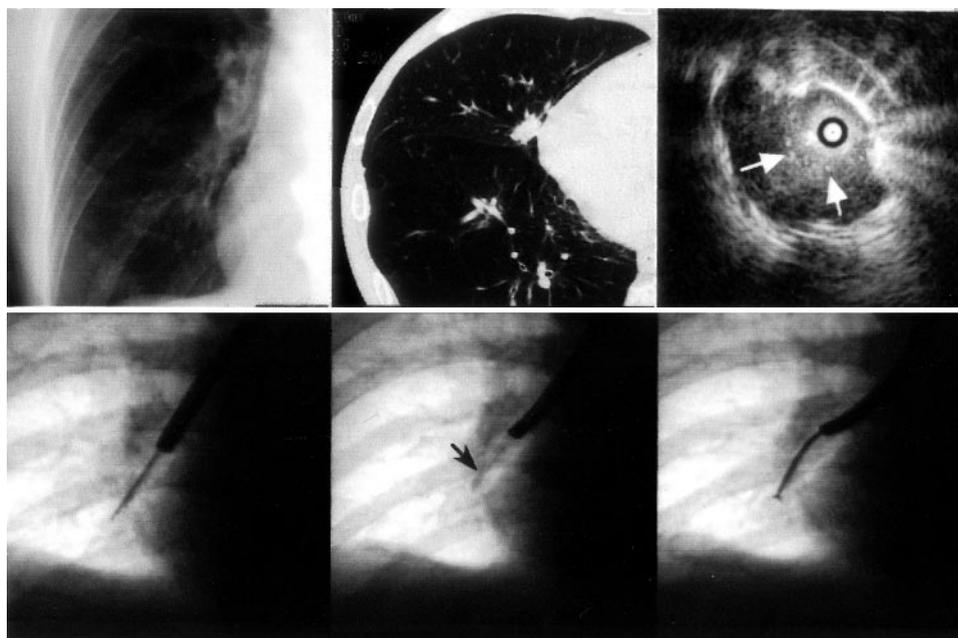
A poorly differentiated adenocarcinoma in the right middle lobe. *Top left:* A lesion is difficult to identify on a plain chest radiograph. *Top center:* Chest CT revealed a nodular lesion, 10×8 mm in size in segment B5b of the right lung. *Top right:* The EBUS image revealed heterogeneous internal echoes (arrow) and an irregular margin of the lesion, with almost no vessels or bronchi within the lesion. *Bottom left:* A miniature probe covered by the guide sheath was introduced into B5b of the right lung. *Bottom center:* A guide sheath (arrow) was left at the site of the lesion. *Bottom right:* A bronchial biopsy forceps was introduced into the lesion.
